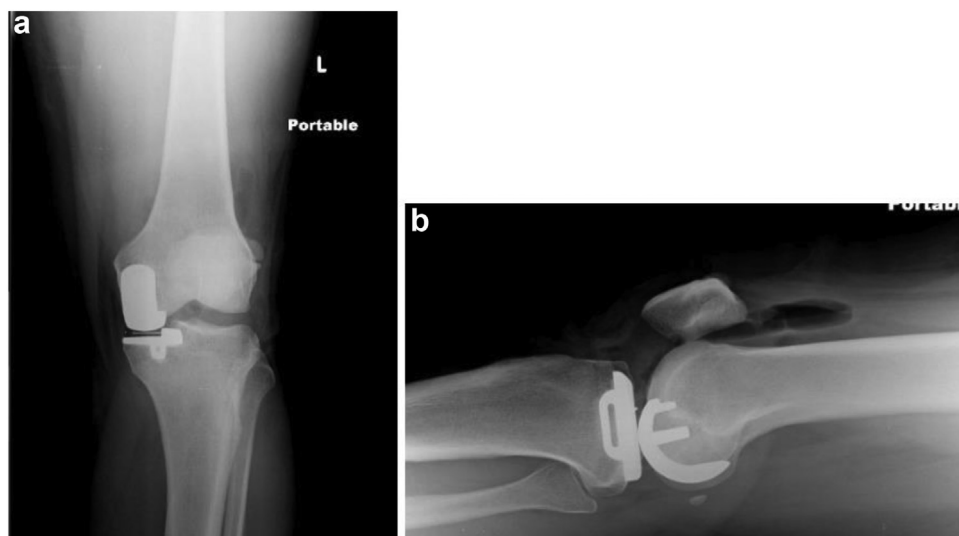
Immediate postoperative anteroposterior (a) and lateral (b) non-weightbearing radiographs of the left knee demonstrating a well-positioned medial UKA.
